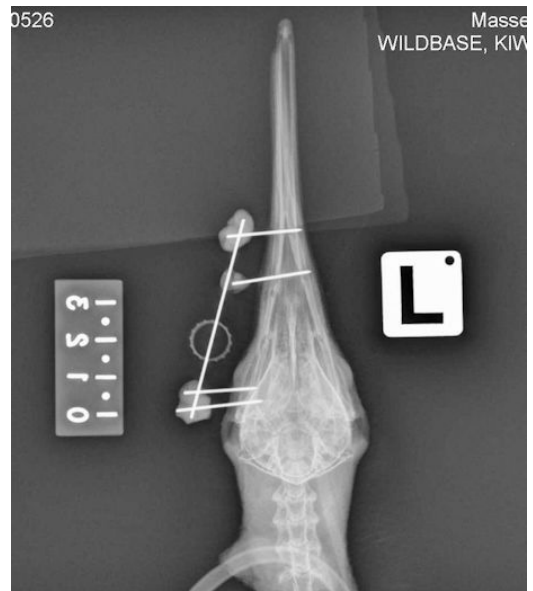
Radiograph with Type I external fixateur in place for caudal mandibular fracture (Note the presence of an oesophageal feeding tube in the lower part of the image).
